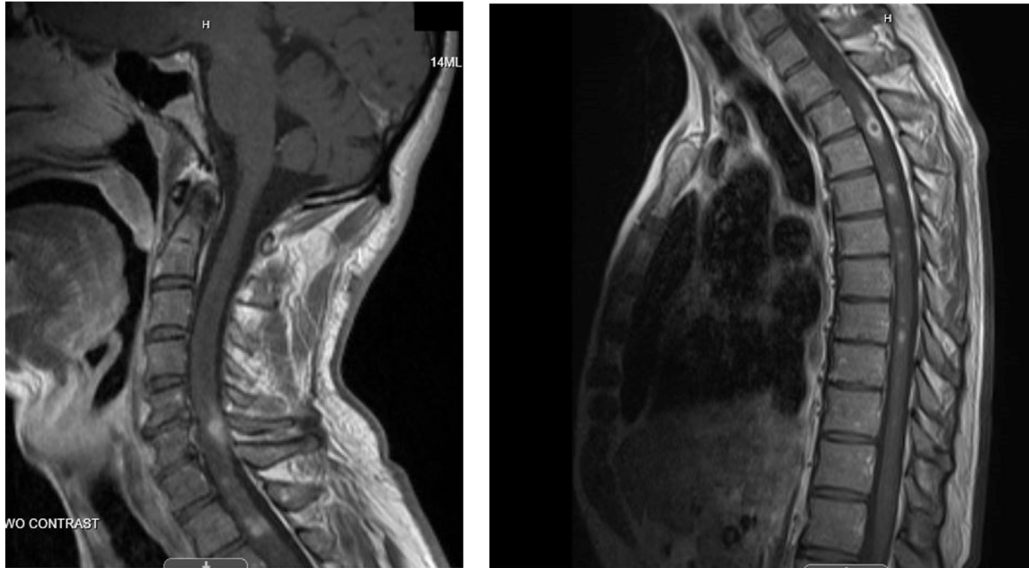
A and B: MRI C and T spine with intramedullary lesions.
